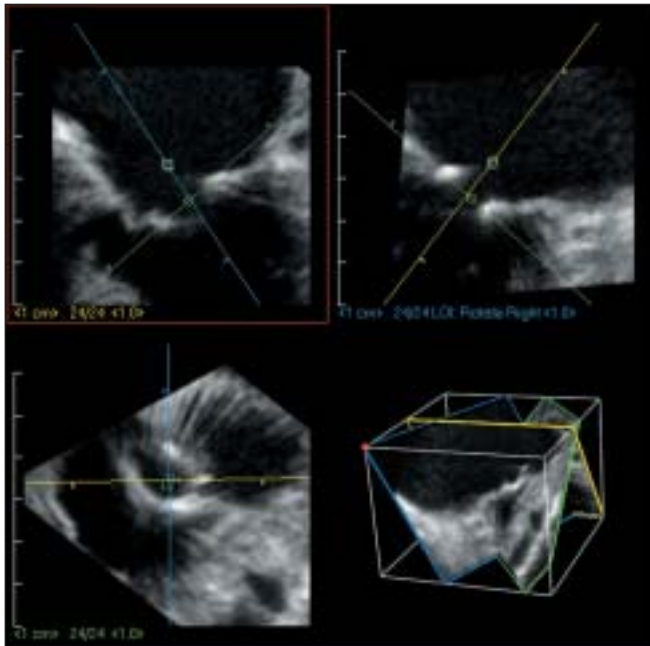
Mitral valve area measurement by planimetry using anyplane echocardiography. Two long-axis cut planes perpendicular to each other (A and B). By guidance of line of intersection, optimal short-axis cut plane was selected: the image that cut the mitral valve just at the cusp tips (C). 3D dataset and spatial alignment of 3 cut planes (D). (From: Langerveld J, Valocik G, et al. Additional value of three-dimensional transesophageal echocardiography for patients with mitral valve stenosis undergoing balloon valvuloplasty. *J Am Soc Echocardiogr* 2003;16:841-9.)
